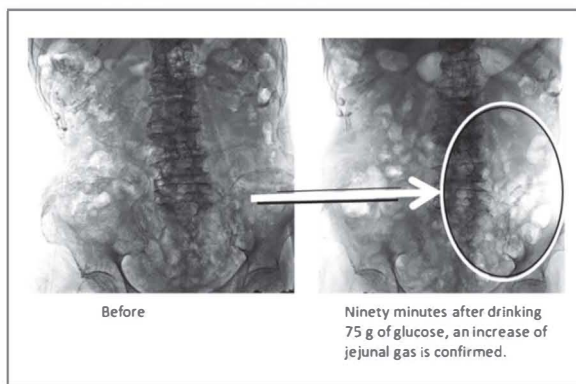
Diagnosis of SIBO via an X-ray image (Personal data of Uno)*
